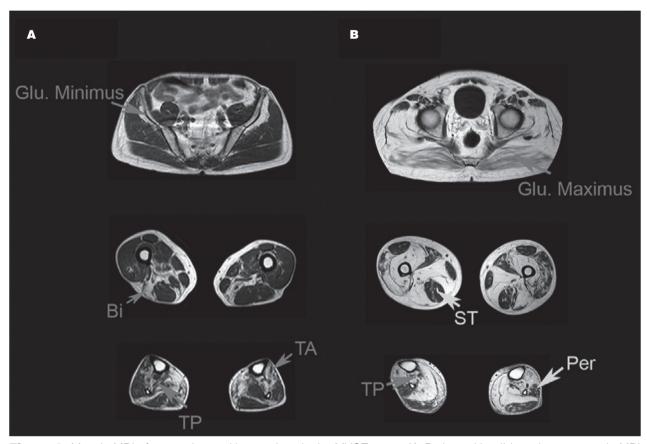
Muscle MRI of two patients with mutations in the MYOT gene. A). Patient with mild weakness: muscle MRI shows mild involvement of gluteus minimus, biceps (Bi), tibialis anterior (TA) and tibialis posterior (TP). B) Patient with severe weakness: muscle MRI shows involvement of all glutei muscles, although gluteus maximus is less involved than gluteus minimus or medius. In the thighs, semitendinosus (ST) is not involved. In contrast, there is a clear involvement of the posterior muscles of the thighs. Tibialis posterior (TP) is more atrophic than peroneus muscle (Per).
